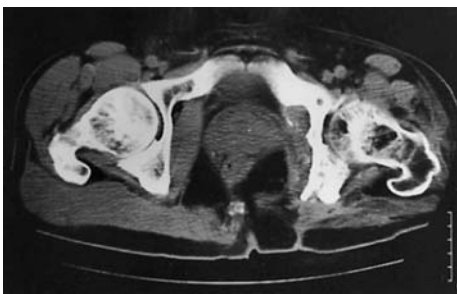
The CT scan confirms the presence of lytic lesions of the ischial tuberosity and the osteoarthritic appearance of the joint
